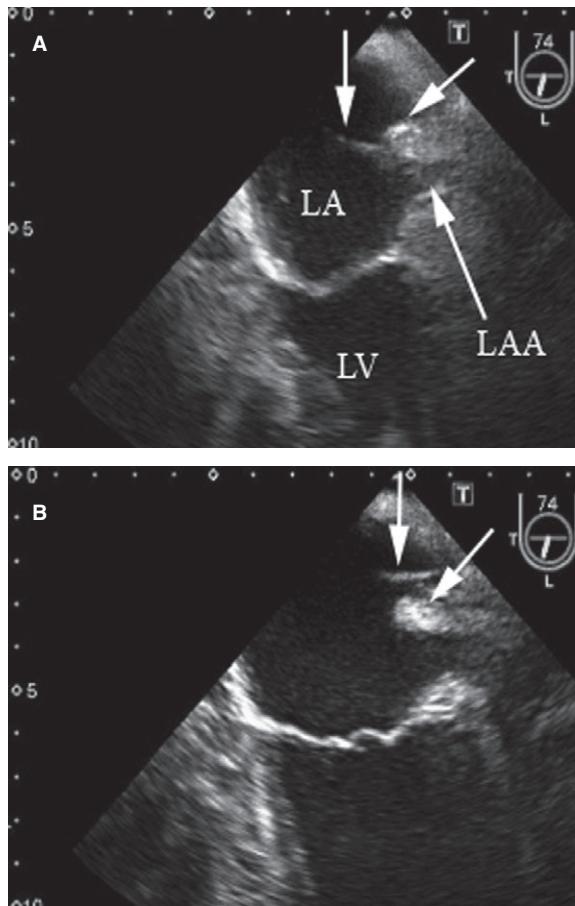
A, B. Transesophageal echocardiography (TEE) documentation of guidewire/catheter tip positioning (vertical arrow). Radiopaque contrast is given to observe position by fluoroscopy, but often differentiation of position within the left atrial appendage (LAA) or LUPV with fluoroscopy is not possible. The guidewire/catheter tip is in (A) the LAA, and (B) LUPV. It is paramount to not confuse the LAA as the LUPV, as perforation of the LAA may occur. (Oblique arrow points toward bulbous ridge between the LAA and LUPV). LUPV = left upper pulmonary vein.
